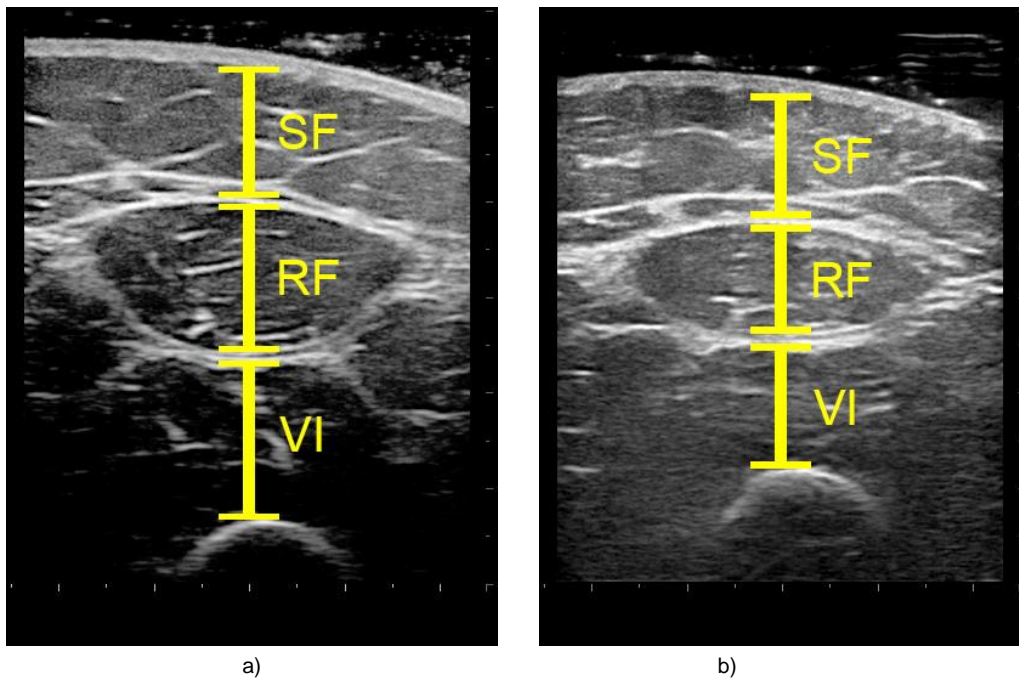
Ultrasound images of the anterior thigh 3 weeks post ACLR of the a) uninjured limb and b) injured limb. SF=Subcutaneous fat, RF=Rectus Femoris muscle, VI=Vastus Intermedius muscle
